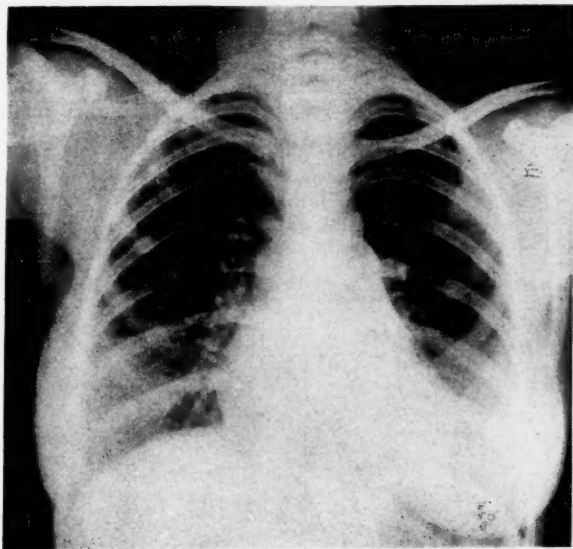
X-ray of chest. Note the prominence of the pulmonary conus. The heart appears slightly enlarged.
